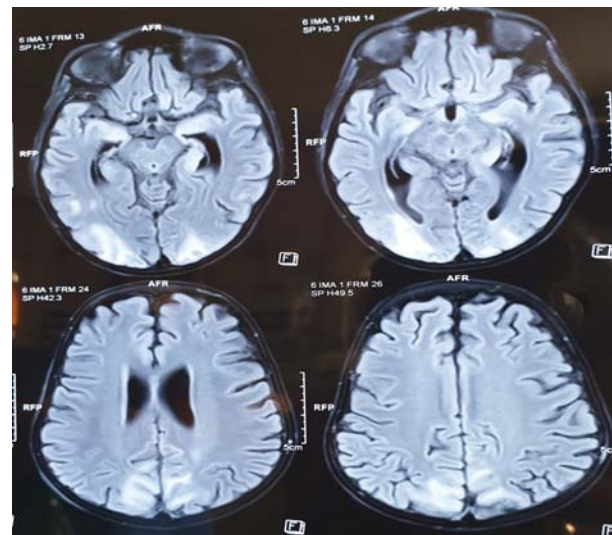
Axial flair plain MRI brain showing white matter hyperintensities involving bilateral parieto-occipital and inferomedial temporal lobes suggestive of ischemia.
